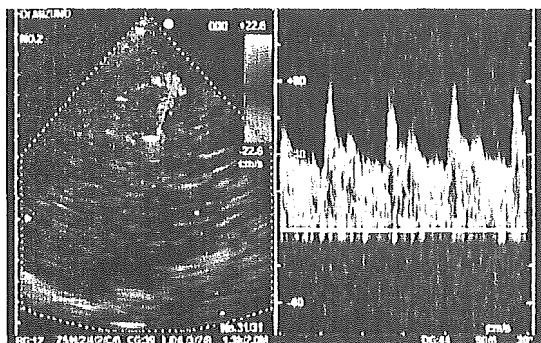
Color mapping and Doppler spectrum of human middle cerebral arterial flow captured by prototype probe.
